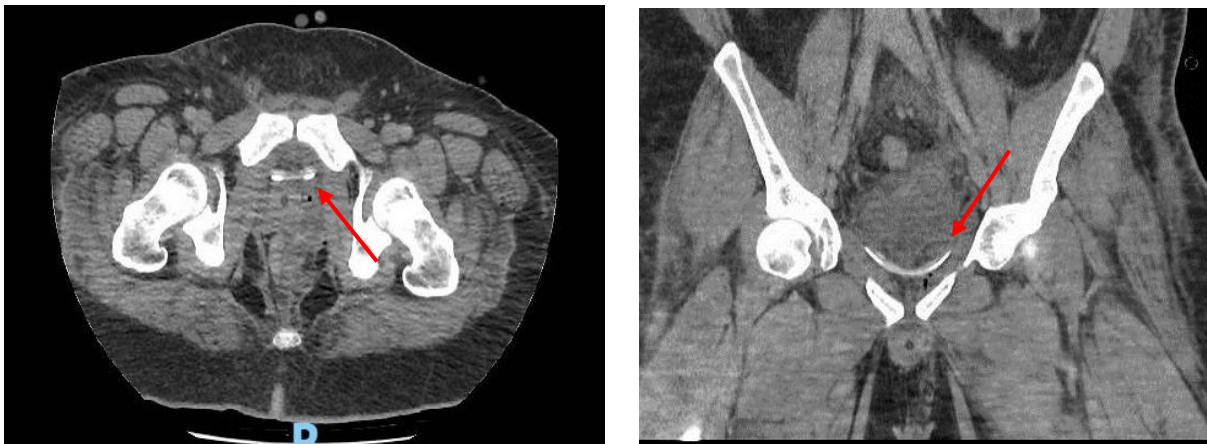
Axial and coronal CT images showing 19 Fr drain placed into retzius space.
